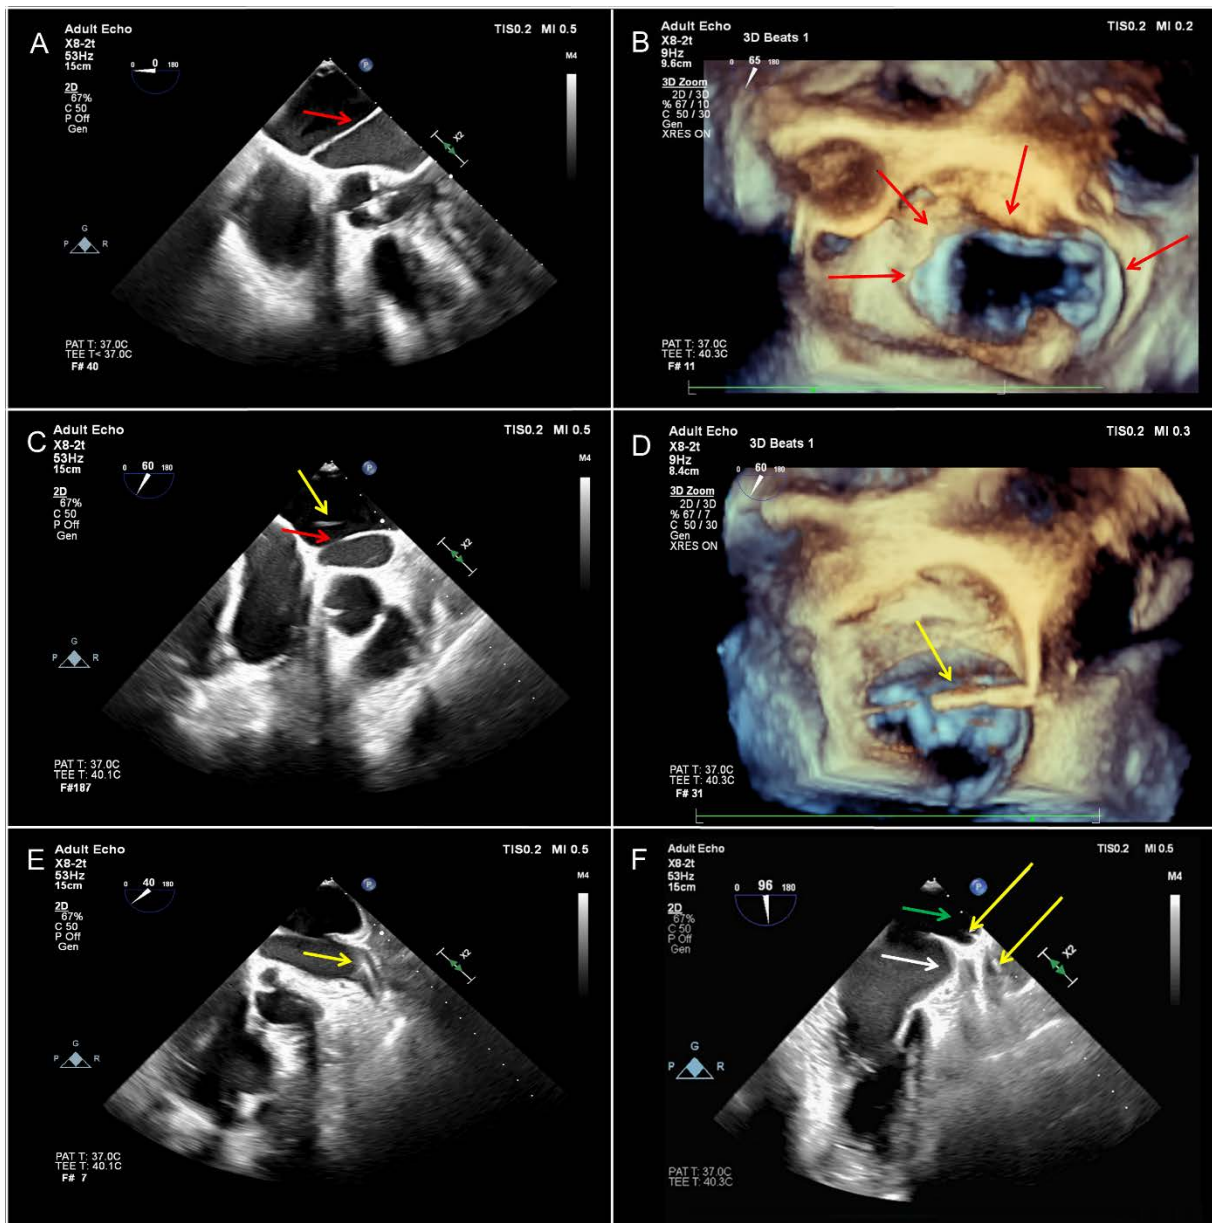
A 2D/3D transesophageal echocardiography (TEE) images of the membrane in the left atrium and transseptal puncture. A. A 2D TEE midesophageal (ME) five-chamber view of the left atrium membrane (red arrow). B. A 3D TEE image of the left atrium membrane (red arrows) with mitral valve leaflets in the background. C. A 2D TEE ME aortic valve short axis view of the guide wire (yellow arrow) in the posterior compartment of the left atrium, behind the membrane (red arrow). D. 3D TEE image of the transseptal sheath and guide wire (foreground, yellow arrow) over the left atrial membrane and mitral valve (background). E. A 2D TEE ME two-chamber view of the guide wire (yellow arrow) in the anterior compartment of the left atrium heading towards the left atrial appendage. F. A 2D TEE ME two-chamber view of the guide wire (yellow arrows) in the posterior compartment of the left atrium (green
